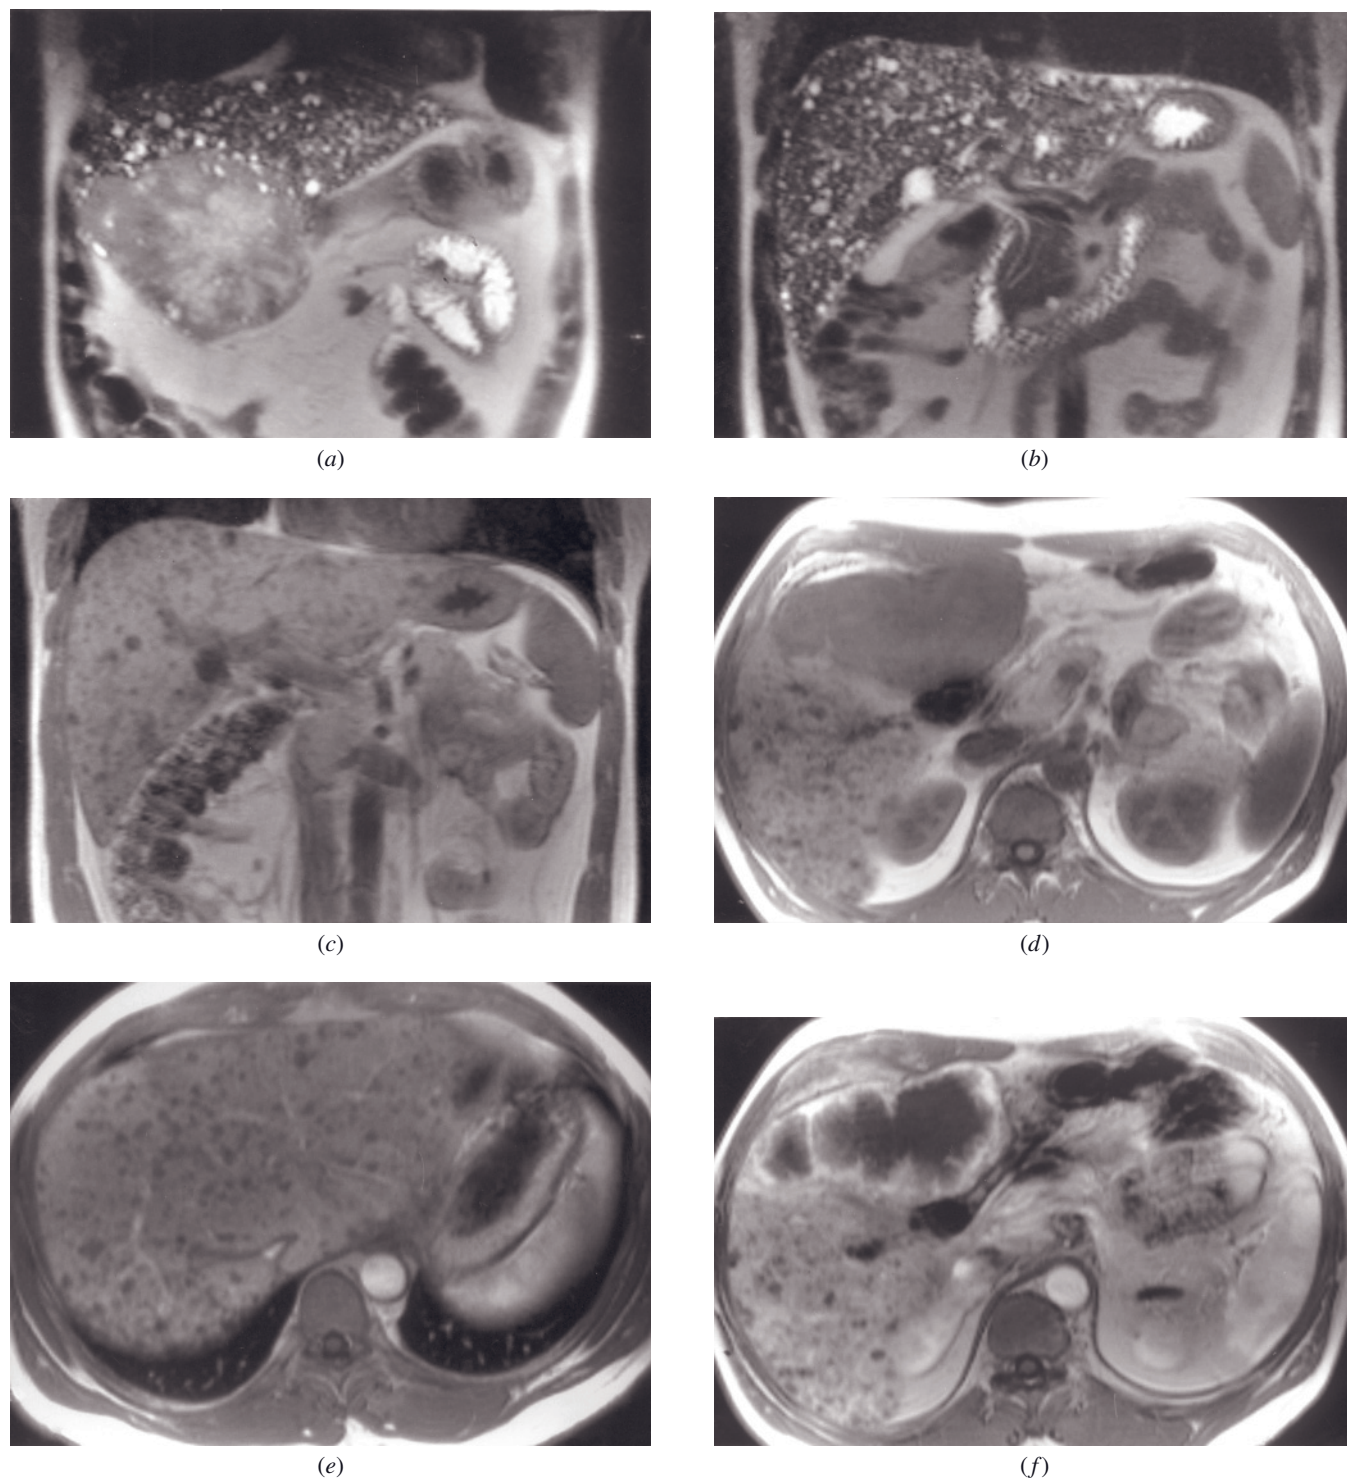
Multiple biliary hamartomas and colon cancer metastasis. Coronal T2-weighted SS-ETSE (*a, b*), coronal (*c*) and transverse (*d*) SGE, and immediate (*e, f*) and 90-s fat-suppressed (*g, h*) postgadolinium SGE images in a patient who has a history of colon cancer. There is a large hepatic mass in segments 4/5 that demonstrates heterogeneous and moderately high signal on
